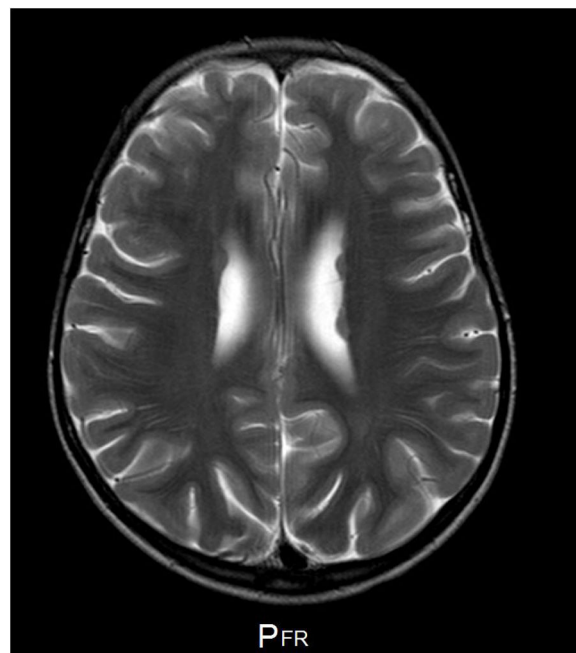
Brain magnetic resonance imaging sequence study performed when the patient was 5 years old. Axial T2-weighted sequence. Periventricular heterotopia.
